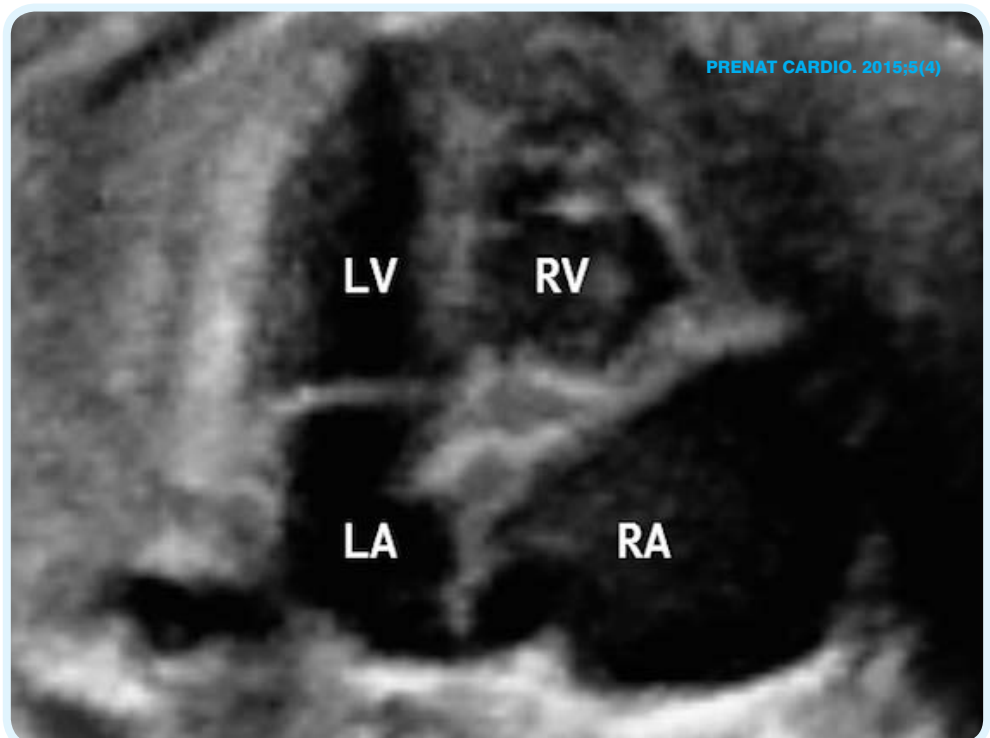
Prenatal echocardiogram: 4 chamber view
